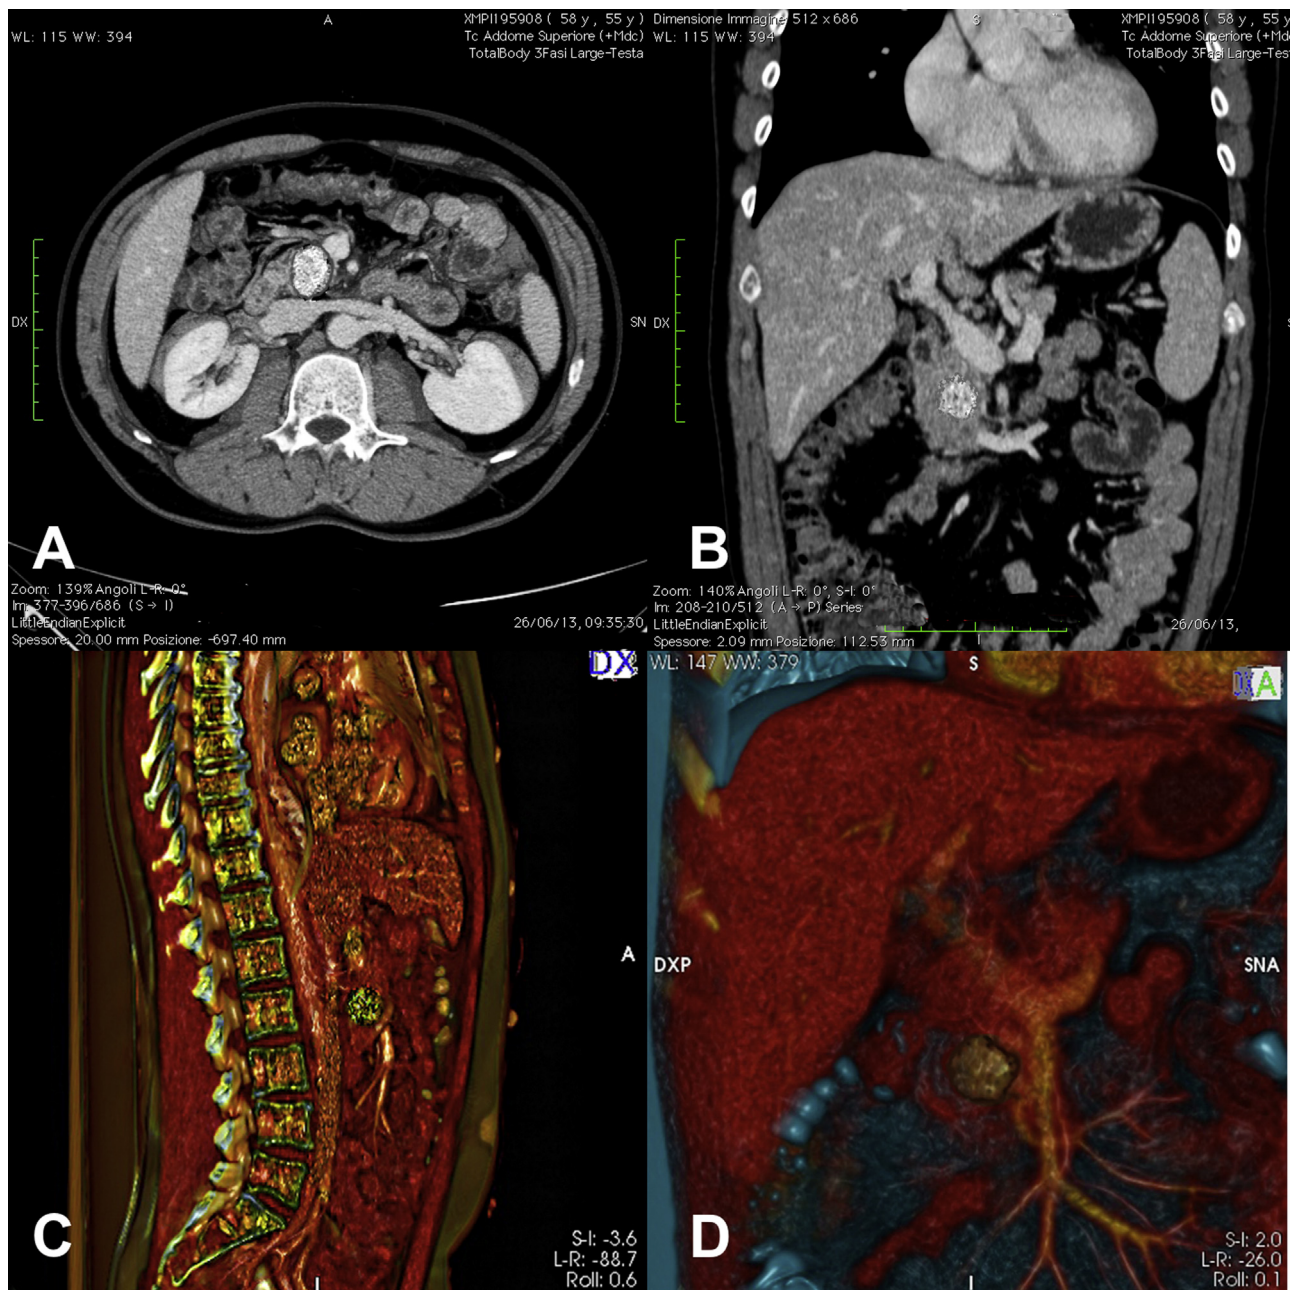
A–B Computed tomography (CT) scan “arterial phase” showed a hypervascularity and slow wash-out. B–C Computed tomography (CT) scan showed a 2.5 cm solid nodule located in the uncinate process of the pancreas.
